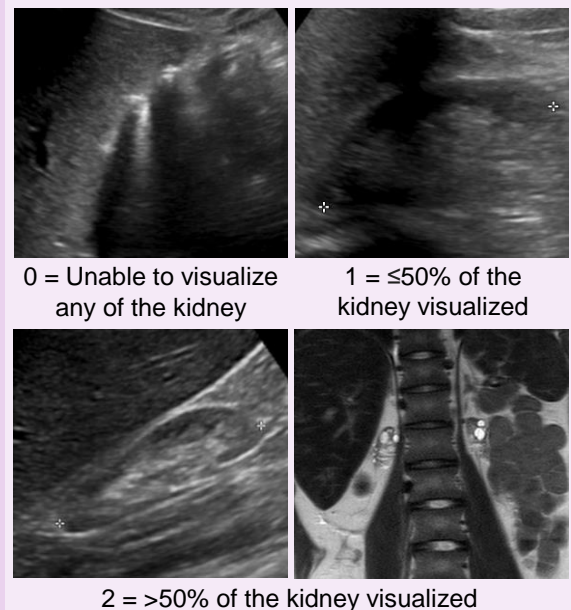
Visualization score of kidney on US / MRI
